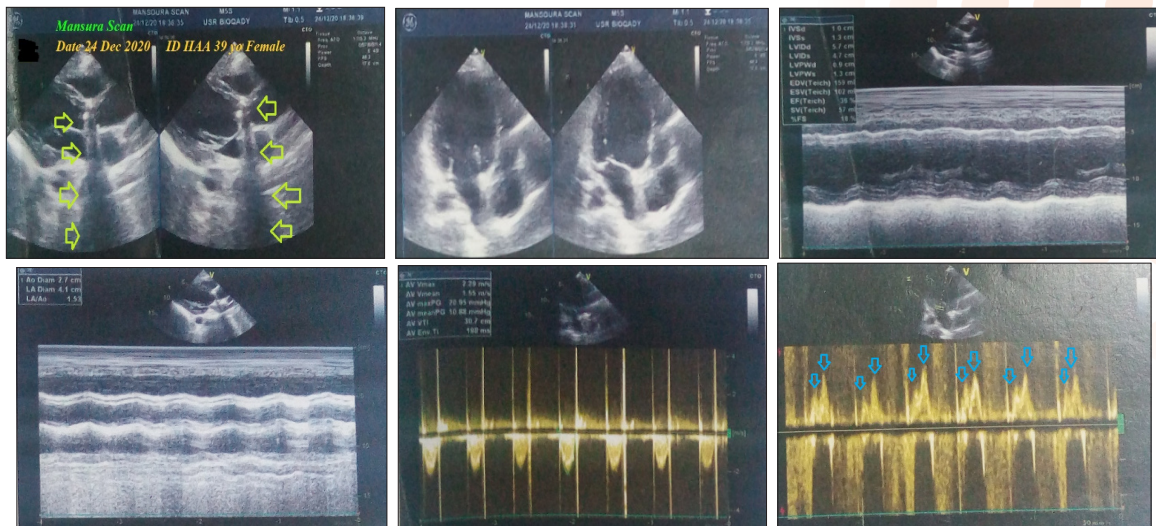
The echocardiography was repeated within 2 months of postoperative aortic valve replacement showing well-suited well-functioned aortic valve metallic prosthesis (lime arrows) with trivial aortic regurgitation (peak/systolic gradient 20/10 mmHg), thickened both mitral leaflets, especially at tips with characteristic doming with mild MR (grade I-II/IV MR), dilated left atrium, dilated left ventricle with EF of 36%, and diastolic dysfunction with reversed E/A% (blue arrows).
